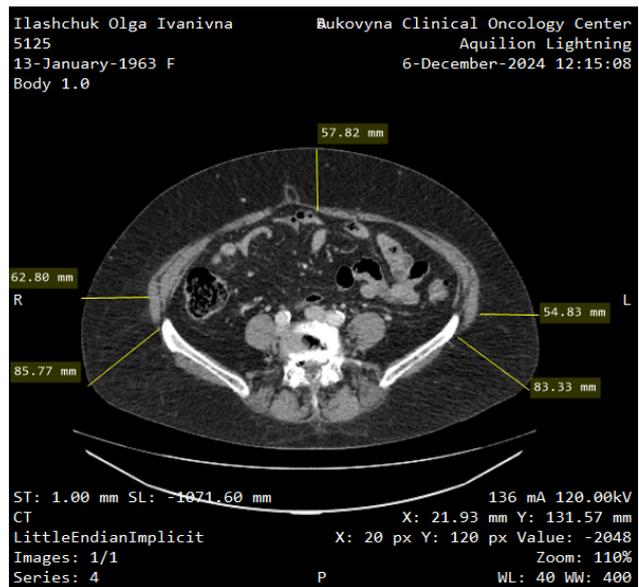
CT scan of patient I., 62 years old with grade II obesity, performed at the navel level. The thickness of the subcutaneous fat tissue ranges from 54.83 to 85.77 mm.
